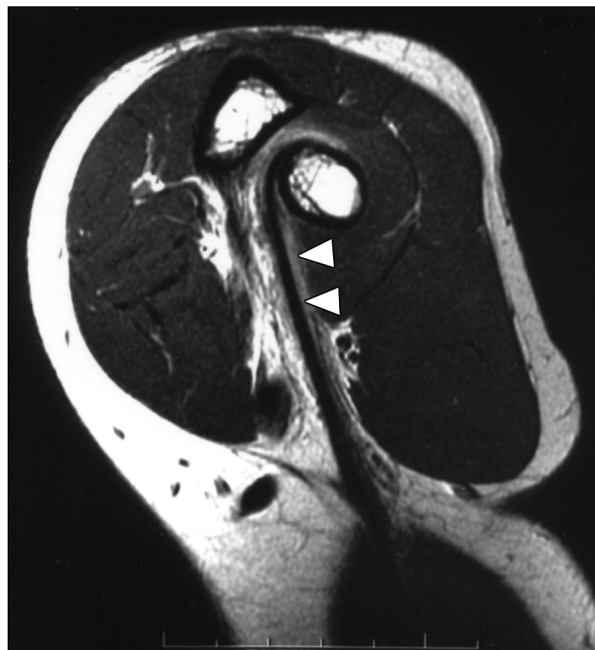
49-year-old man with partial tear of right distal biceps brachii tendon. Proton density-weighted MR image (TR/TE, 3,000/34) of flexed abducted supinated view of partial tendon tear shows linear abnormal signal adjacent to intact tendon extending from insertion to mid part of tendon and blurring of fat adjacent to tendon. Arrowheads = linear abnormal signal in distal tendon.
